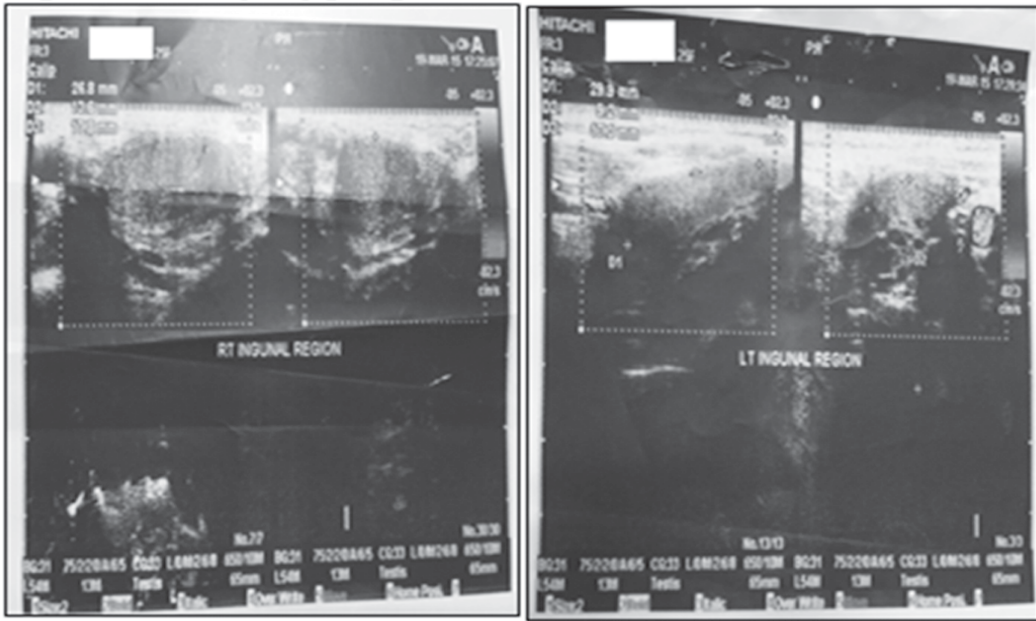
Ultrasound image of right and left inguinal regions.
